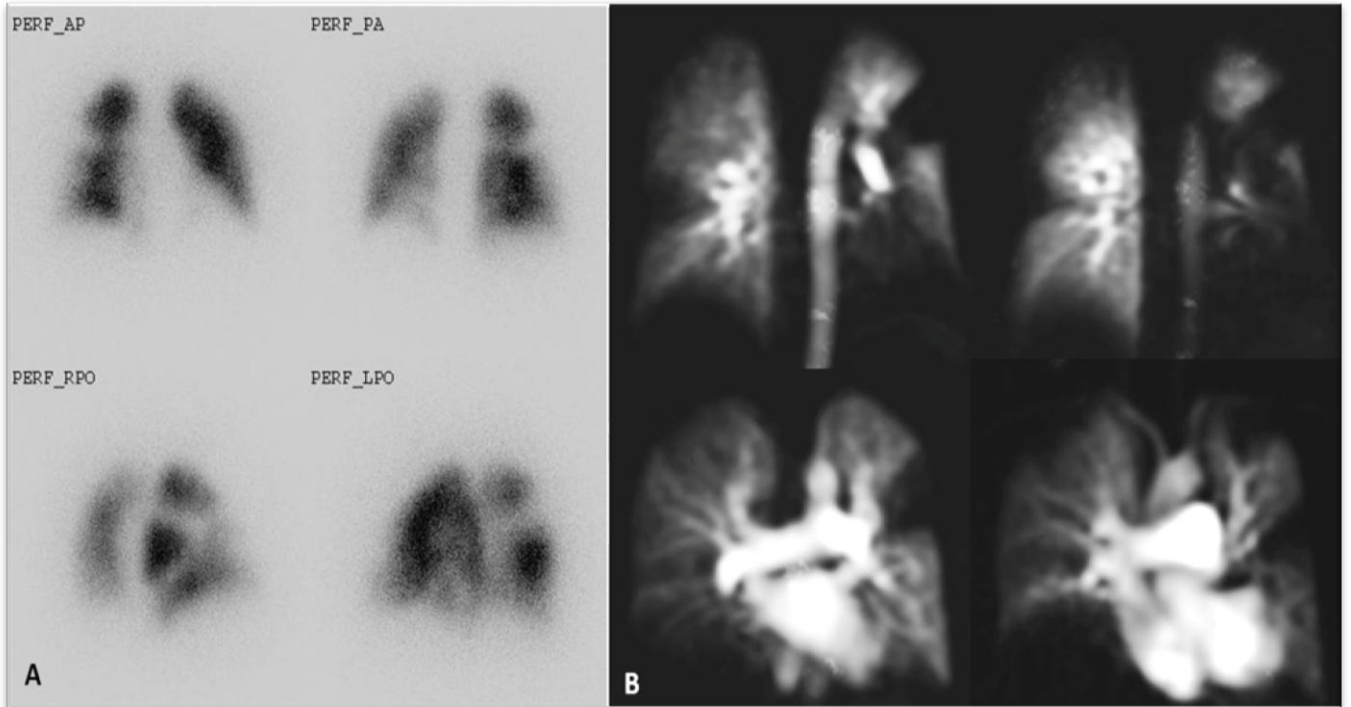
Bilateral multiple segmental perfusion defects on perfusion scintigraphy (A) and coronal MR perfusion images (B) consistent with a diagnosis of Chronic Thromboembolic Pulmonary Hypertension
